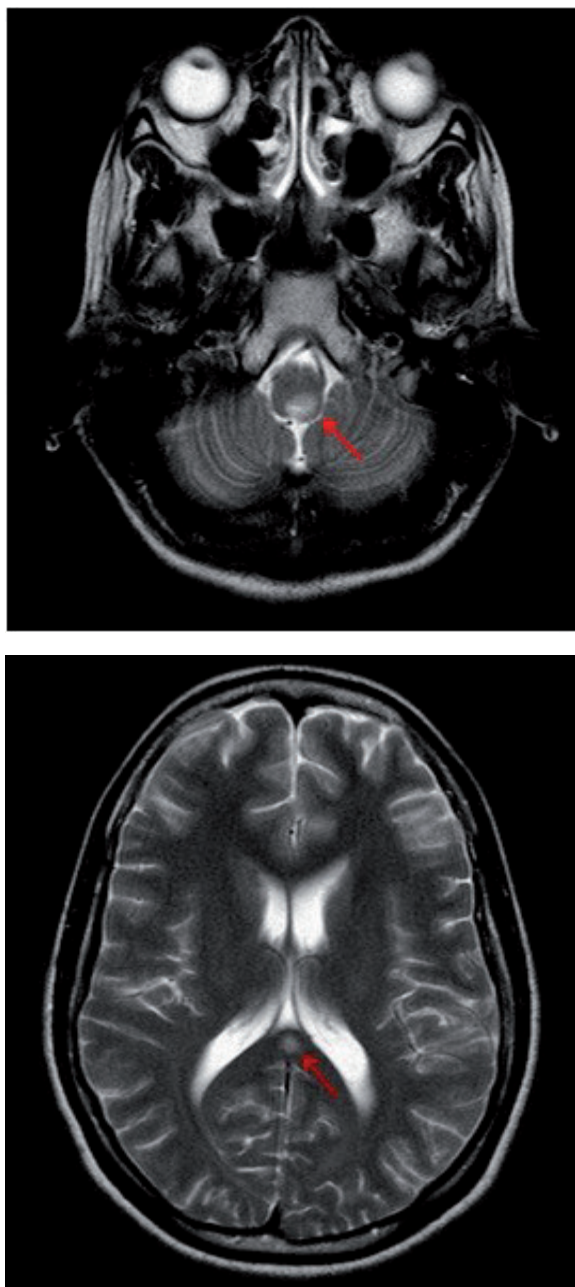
T2-weighted MRI of the brain shows hyperintense lesion in the dorsal medulla and in the splenium of corpus callosum.
